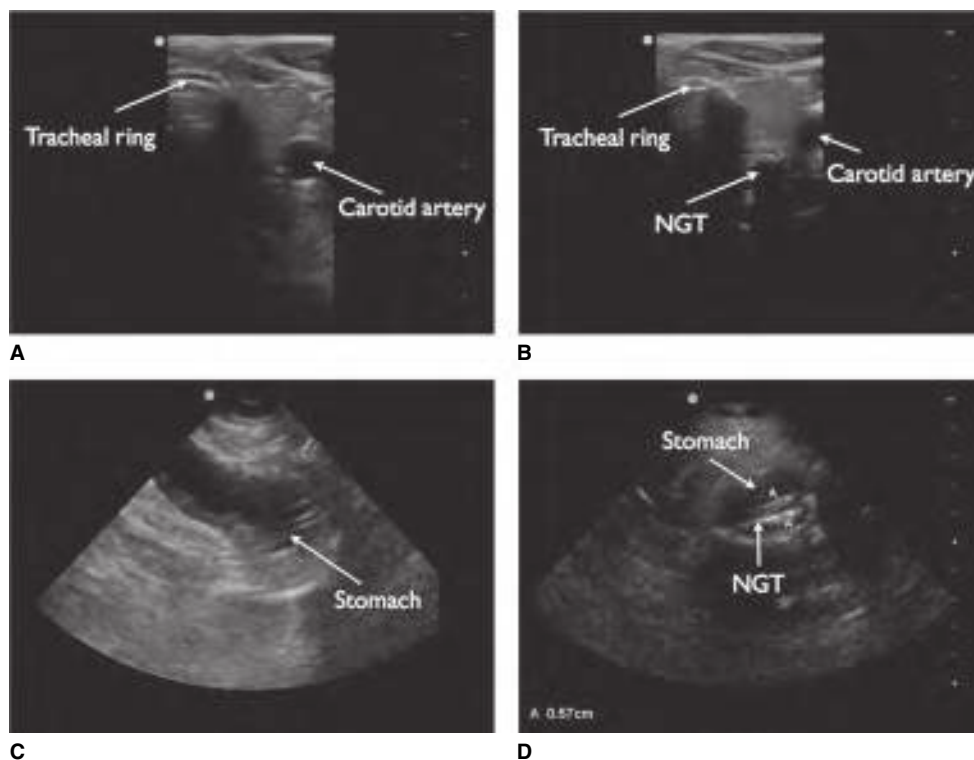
Ultrasound transverse images before and after an NG tube (NGT) insertion. A. The neck. B. The neck after placement of an NG tube. C. The epigastric area demonstrating the distended fluid-filled stomach. D. The epigastric area with the NG tube visible in the stomach. (Used with permission from reference 52.)
